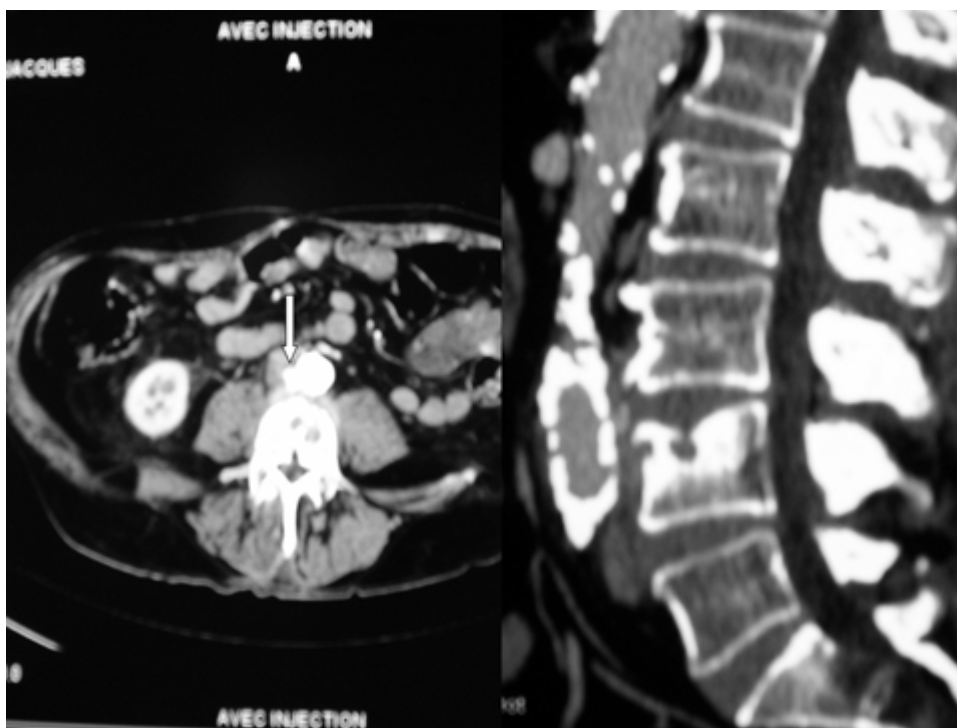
CT with intravenous injection shows erosion of the upper plate of L4 vertebral body and rupture of the abdominal aortic aneurysm (arrow).
